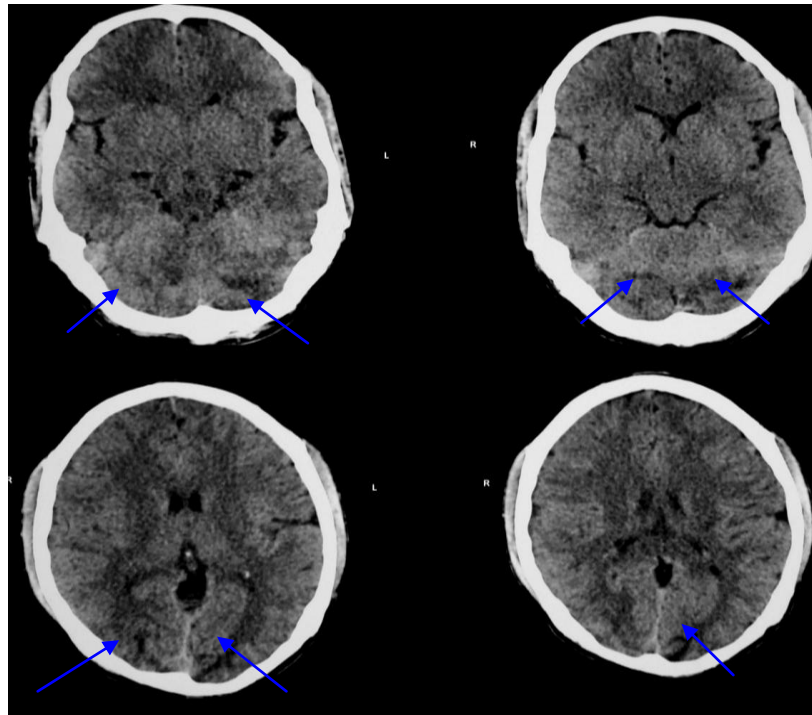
CT Brain Showing cerebral edema with effaced sulcal spaces (arrow) predominantly in cerebellar hemispheres and occipital region with multiple hypodense lesion (arrow) in same region.
